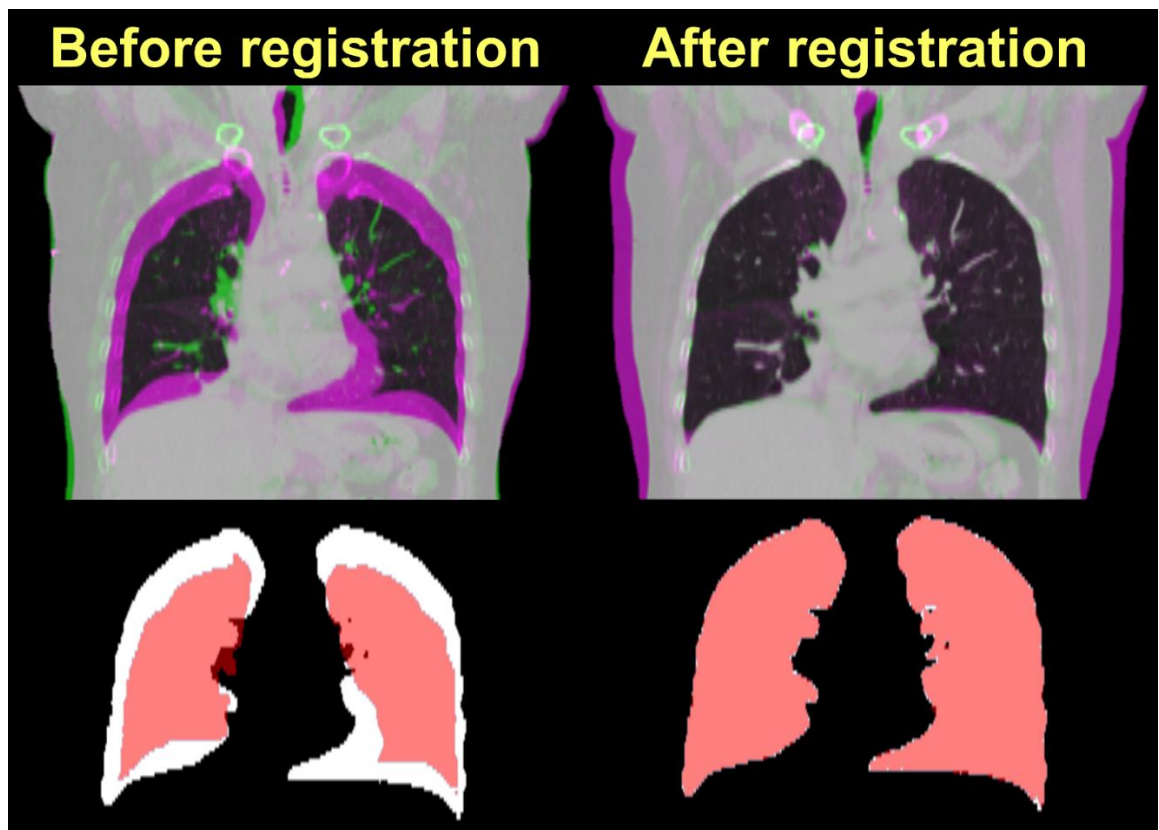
Example coronal slice of expiratory CT image overlaid on inspiratory CT image before (left) and after (right) diffeomorphic image registration for the intensity images (top) and lung segmentations (bottom).
